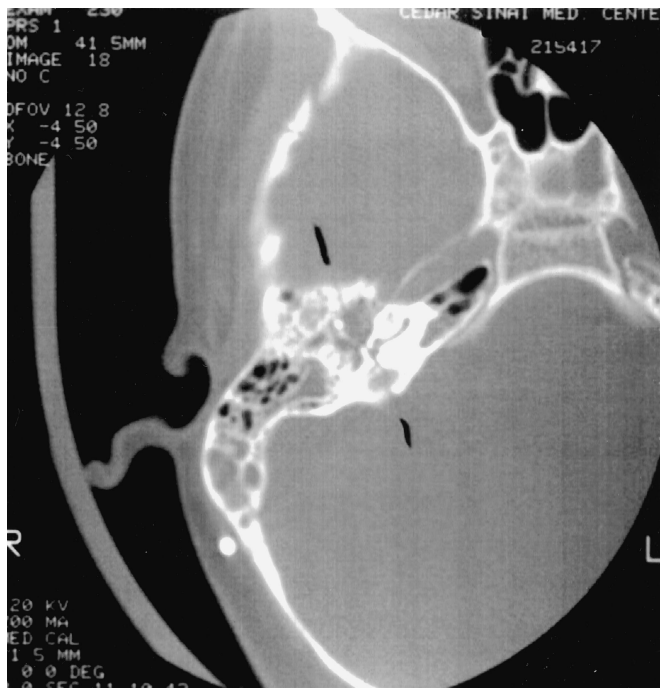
High-resolution temporal bone CT scan showing a transverse temporal bone fracture in a patient who was struck on the occiput with a blunt object.
